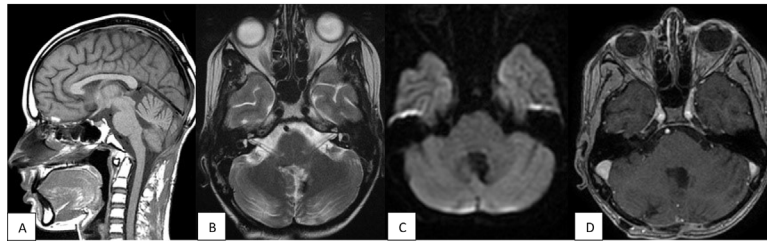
Encephalic MRI: Sagittal T1 (A), Axial T2 (B) diffusion (C) injection of gadolinium (D) at the end of the treatment showing no evident residual tumor.
